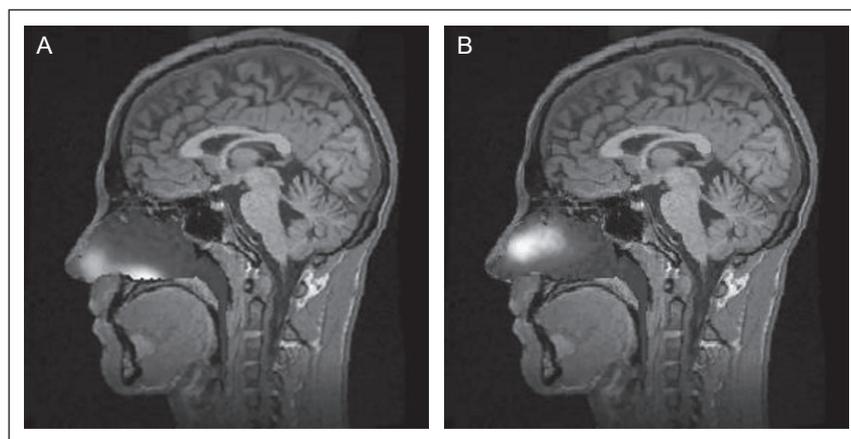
Gamma camera image of deposition 2 minutes after delivery of a solution of $^{99m}\text{TcO}_4$ in saline using a conventional liquid spray device (A) and ^{99m}Tc -labeled lactose powder delivered using the Breath Powered device (B). The image of the nasal cavity is superimposed on the corresponding sagittal MRI section. The images were from the same subject after each method of administration.
